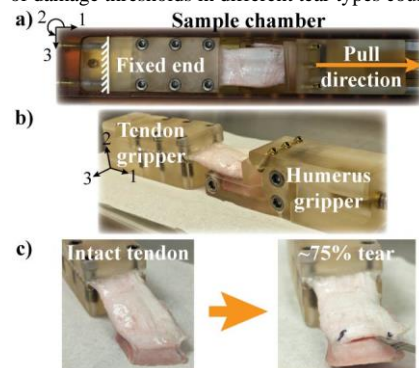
a) MRI compatible apparatus, showing loading direction. b) Fixture. c) Sample conditions.
